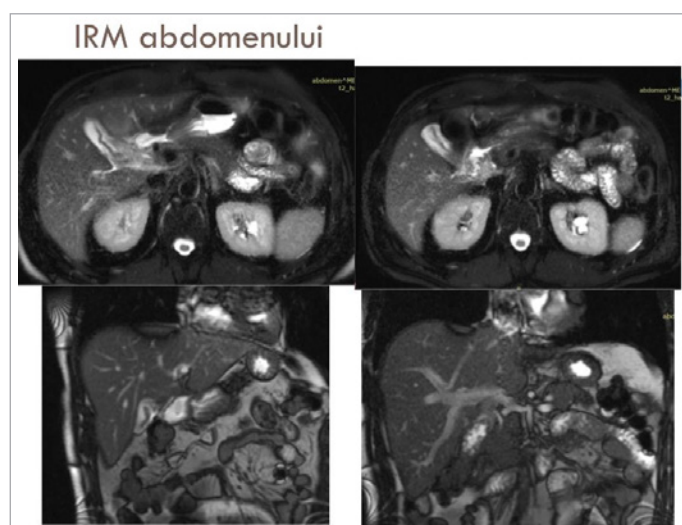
MRI of the abdomen.
